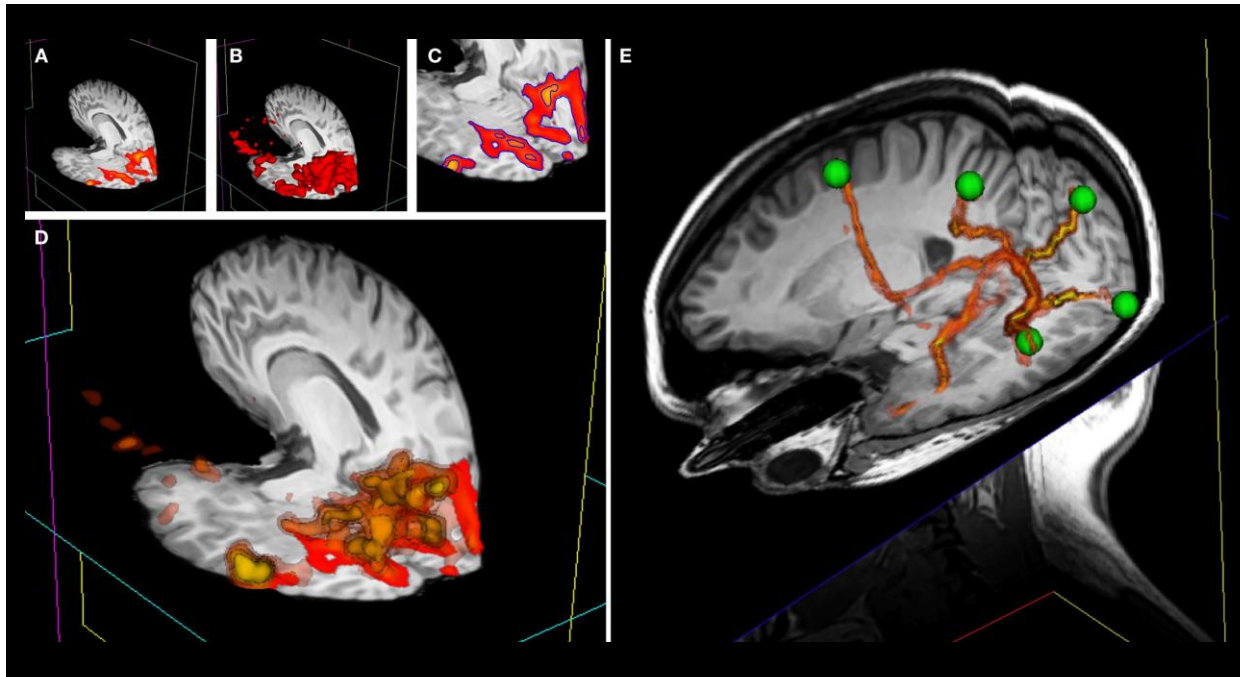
A novel technique for rendering 3D volumetric statistical maps. (A) Standard technique for displaying statistical data on 2D planes. (B) As in Figure 4, isosurface techniques are used to extract a single surface at a particular scalar value in the volumetric data resulting in a 3D representation of the statistically significant volume at a given threshold. (C) A 2D depiction highlighting how isosurface techniques are capable of ‘outlining’ multiple scalar values simultaneously, iso-lines shown here in blue. (D) Multiple isosurfaces can be extracted and rendered simultaneously, with distinct color mapping of all boundaries between the lowest and highest extracted boundary; here the lowest values are rendered with higher transparency so that underlying, higher-threshold surfaces can be seen simultaneously. (E) The technique described in (D) is useful for probabilistic MRI tract visualization: output from FSL’s Probtrack toolbox is rendered using the 3D overlay technique as yellow-to-red isosurfaces. The green spheres indicate the seed and target points. Adapted from Gouws et al., 2009.
